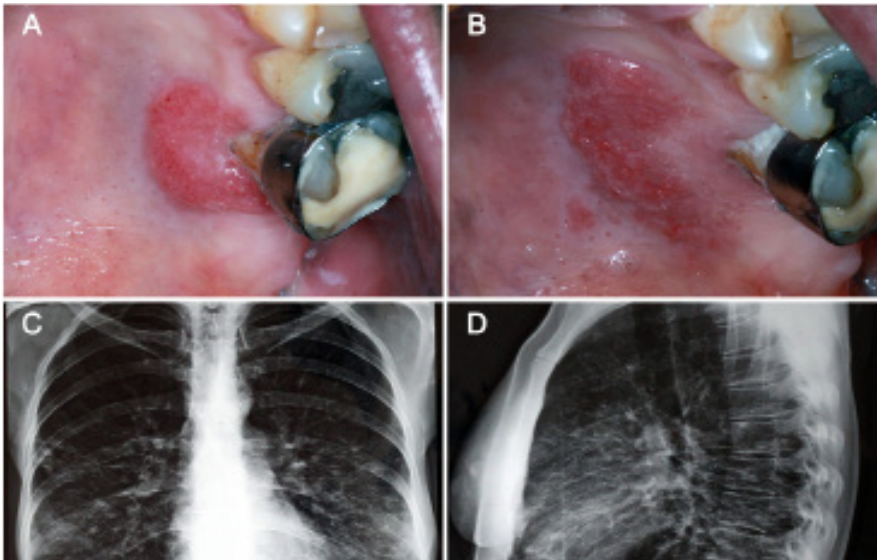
Clinical aspect of oral paracoccidioidomycosis. (A) Initial presentation of the lesion. (B) One month later an expansion of the eroded area was observed. Radiographic aspect of lungs with radiopaque diffuse areas. (C) Posteroanterior view. (D) Lateral chest x-ray.
